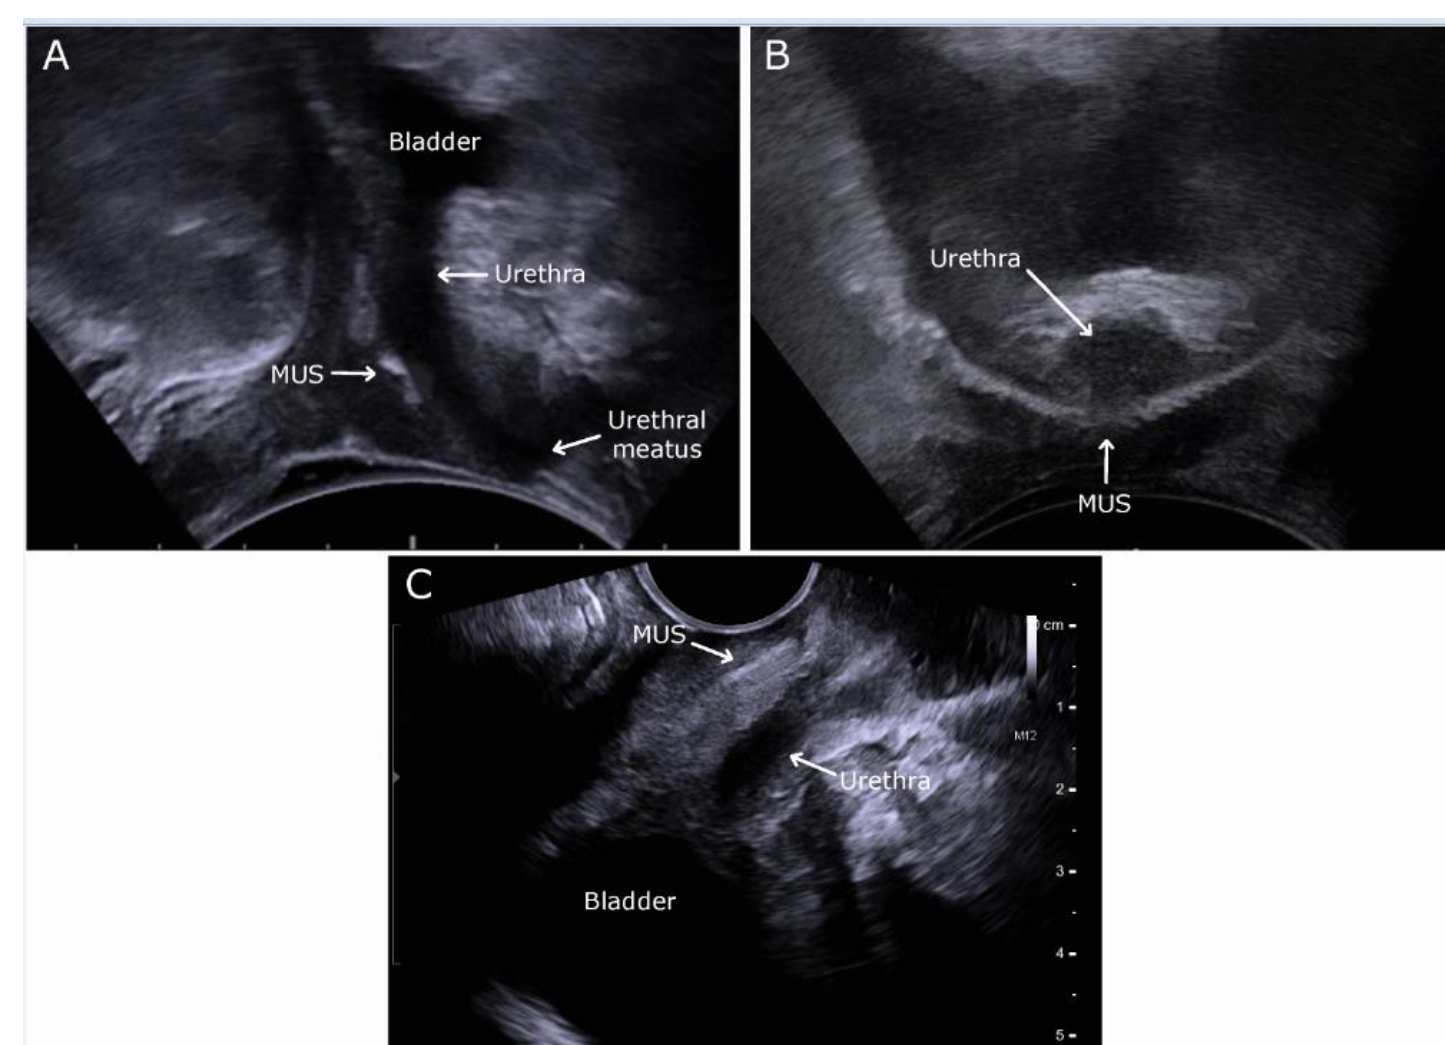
Sonographic assessment of a correct MUS. A: Mid-sagittal plane obtained by transperineal ultrasound at rest with a convex probe (type 8802, Fleshfocus 400, BK Medical). B: Transverse plane obtained by transperineal ultrasound at rest with a convex probe (type 8802, Fleshfocus 400, BK Medical). C: Mid-sagittal plane obtained by transvaginal ultrasound at rest by endovaginal probe (type 8819, Fleshfocus 400, BK Medical). MUS: mid-urethral sling.
